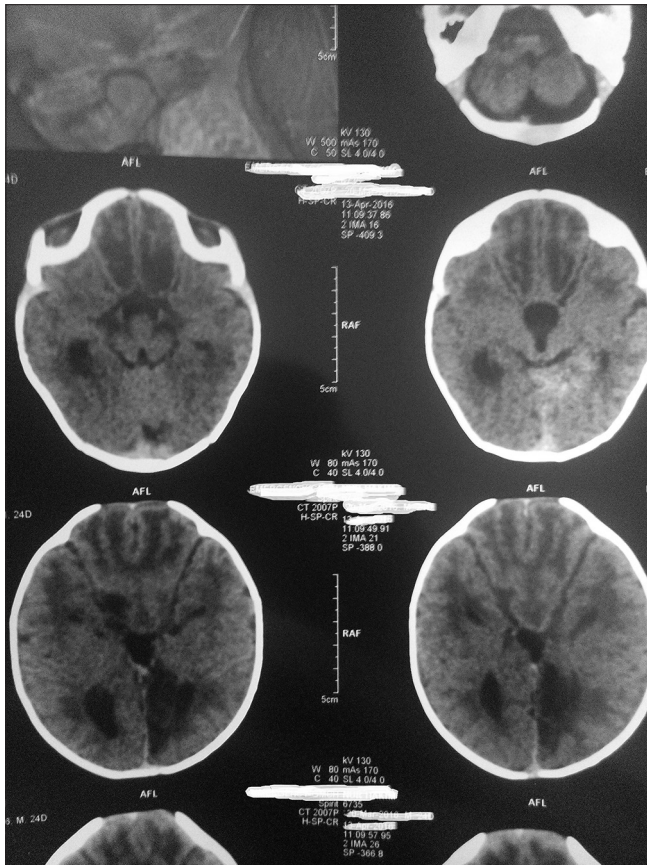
Computed tomography scan of the diprosopus case
